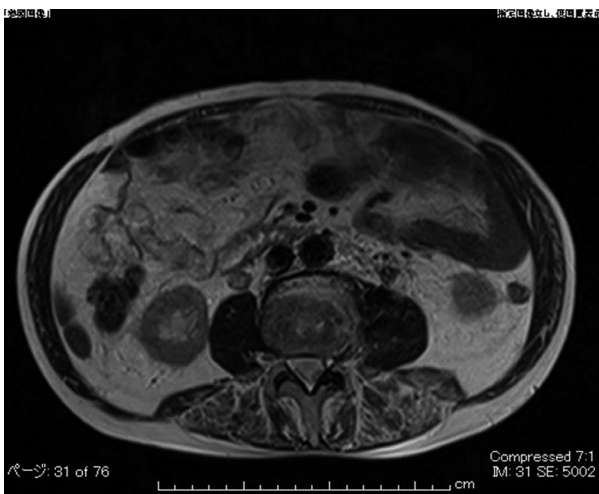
Axial T2-weighted image showing postinflammatory fibrosis around the left ureter at the L3–4 level.
